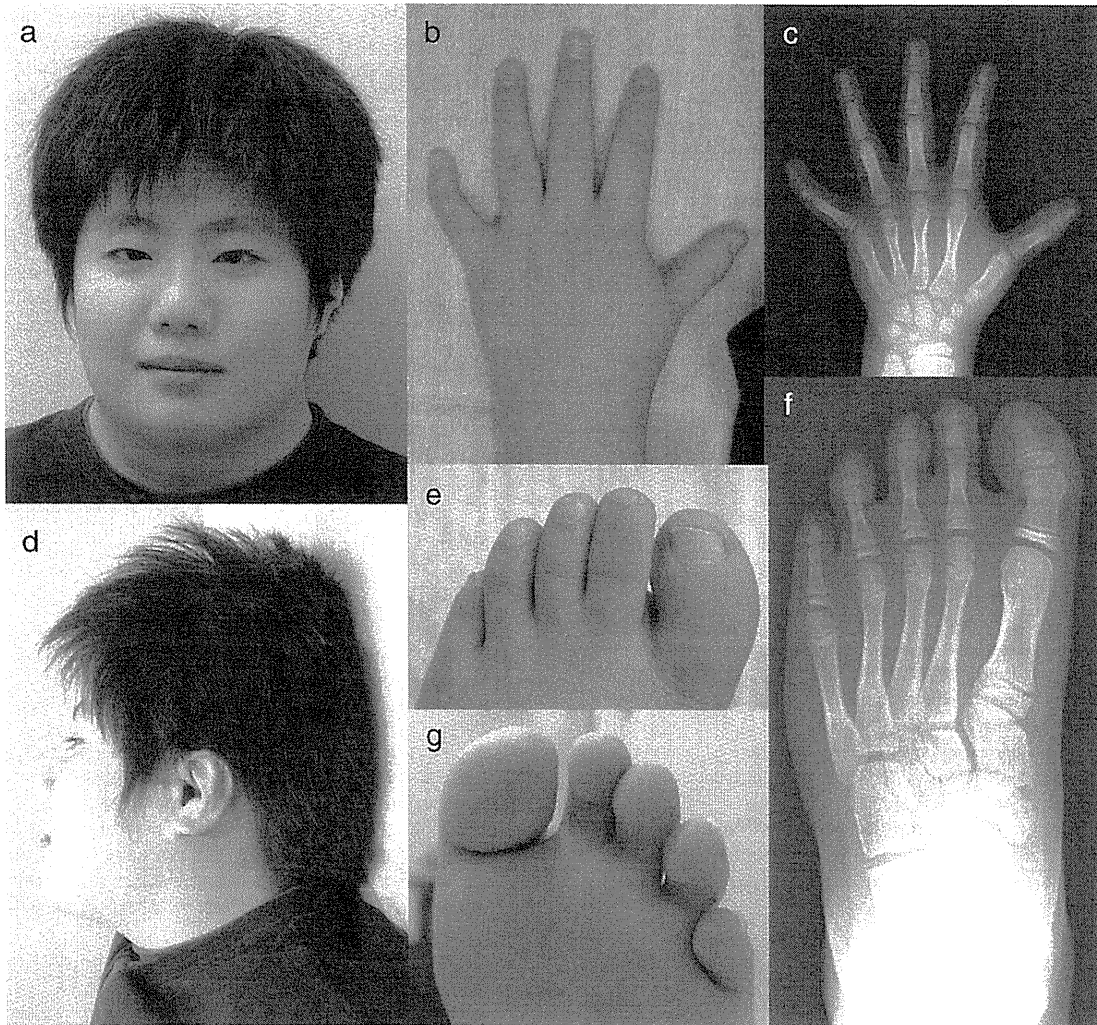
Facial expression and limb abnormalities in the present patient. (a) Mildly dysmorphic facies with bifrontal narrowing. (d) Lateral view demonstrating low-set posterior rotated dysplastic ears. (b) Left hand showing short digits and clinodactyly of the fifth finger. (c) X-ray showing small pointed distal phalanges and hypoplasia of the middle phalanx of the fifth digit. (e,g) Left foot showing a short, curved and broad great toe. (f) X-ray showing hypoplasia of the middle and distal phalanges.
